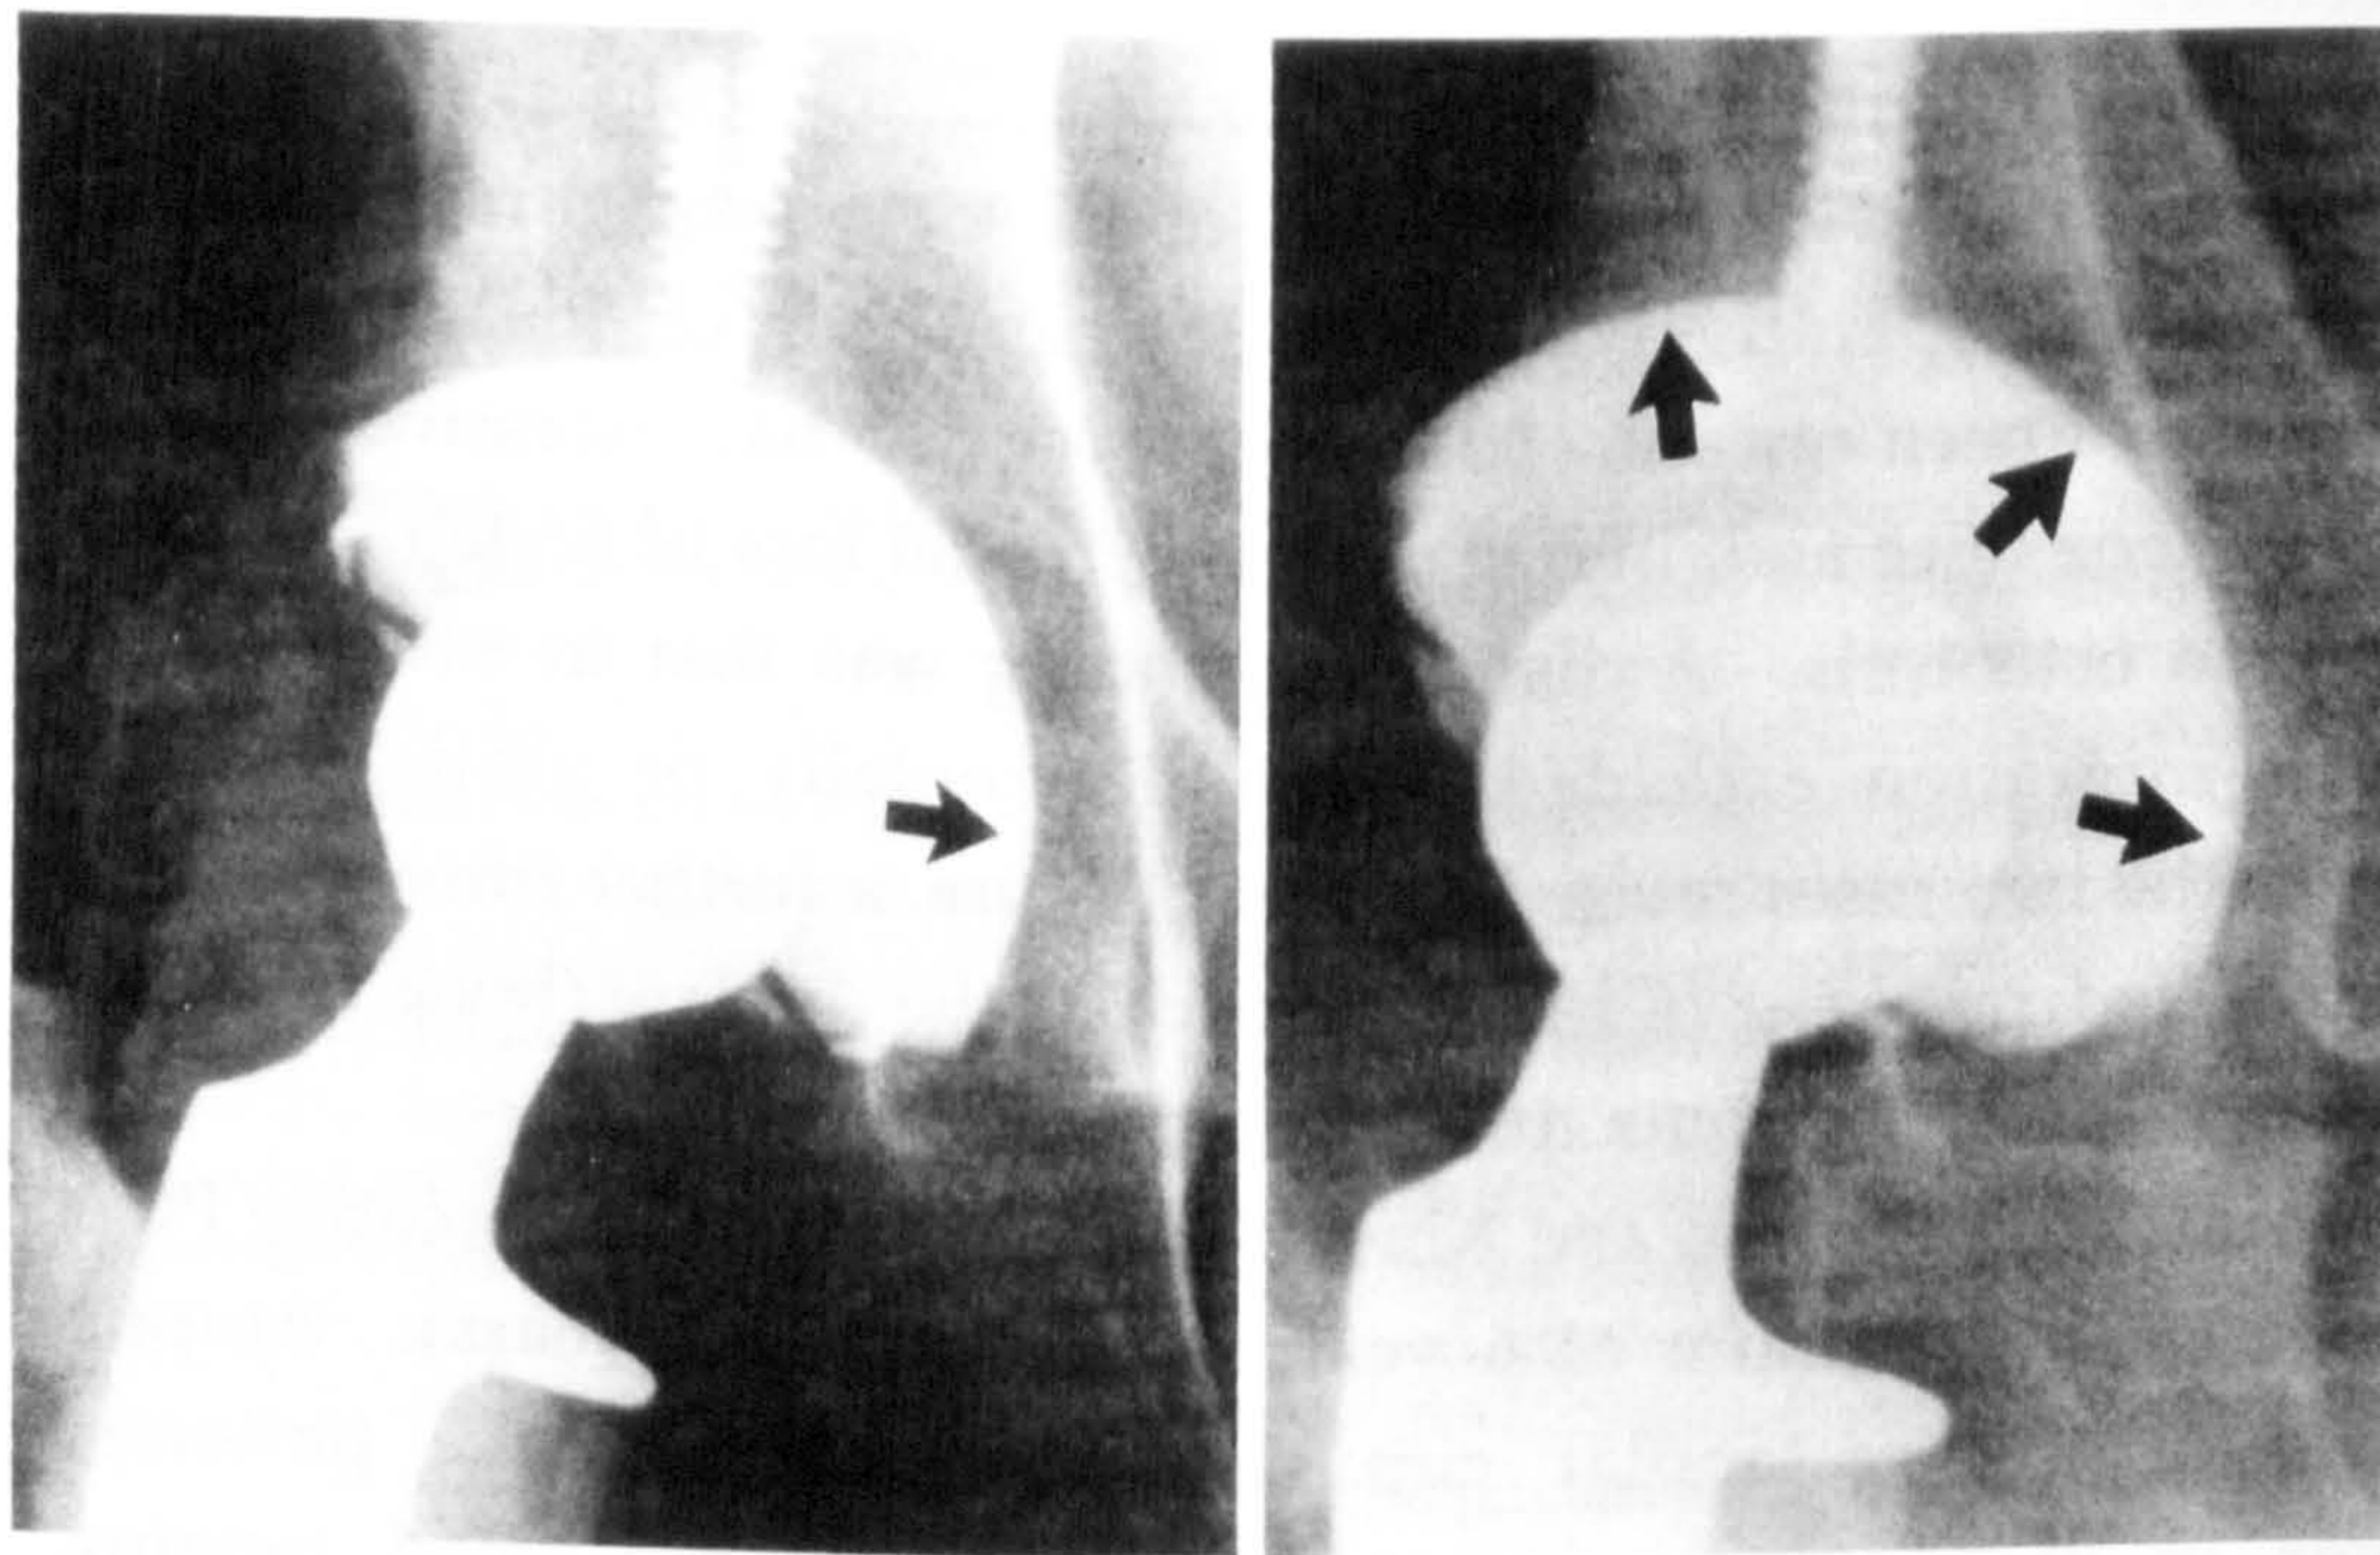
A case reported by Schmalzried et al (1992) in which a porous coated titanium cup demonstrated evidence of excellent circumferential contact with bone on the early postoperative radiograph (left). However, after 67 months, bony contact was absent in all zones of the interface (arrows), with the appearance of a thin, continuous radiolucent line.
